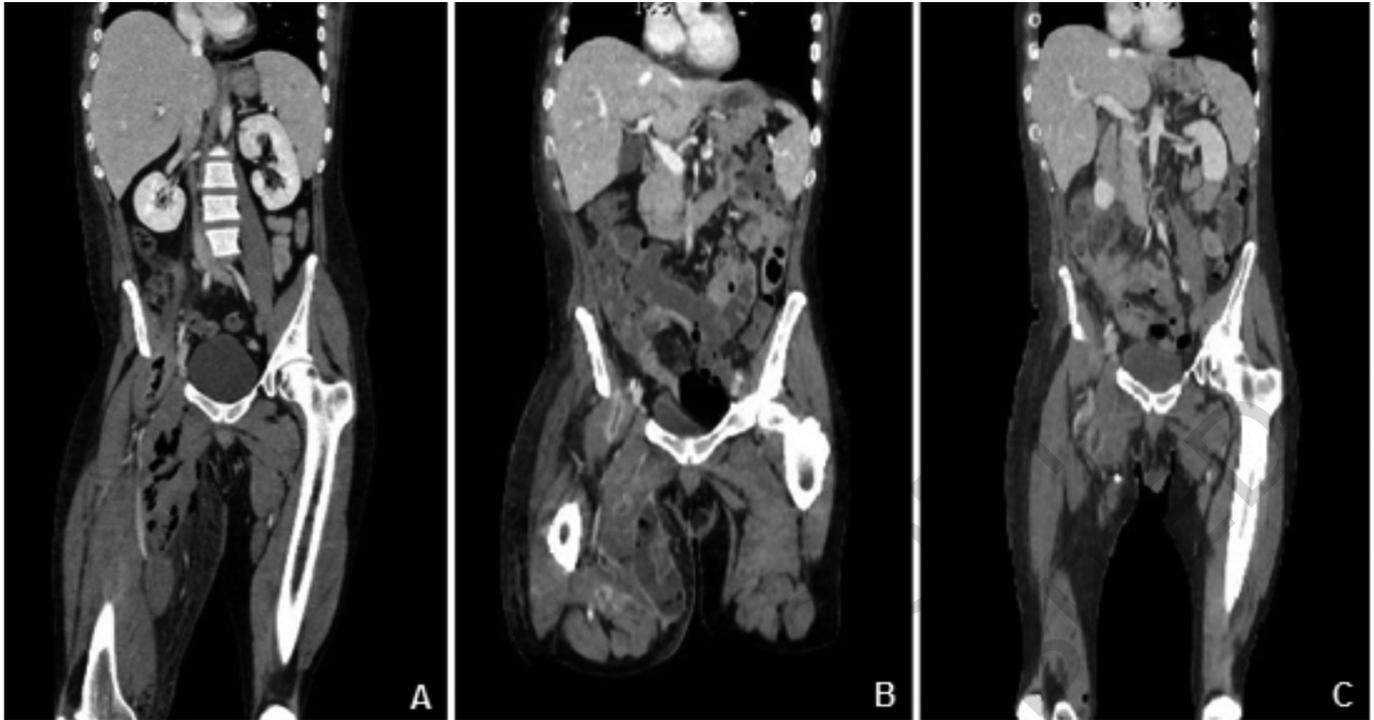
A) CT scan upon admission revealed a large complex air-fluid collection within the right iliac region, involving terminal ileum, right retroperitoneum and right lateral abdominal wall towards the inner edge of the right thigh; B) CT scan, seventeen days after surgery, showed few residual air-fluid collections within the inner edge of the patient's right thigh, involving iliacus, pectineus, adductor and sartorius muscles towards both the subcutaneous and cutaneous tissues anteriorly. Therefore, the radiologist using the imaging guidance placed a 10 French percutaneous abscess drainage in the biggest and declivous collection of the right thigh; C) One week later a new CT scan showed a significant downsizing of the right inferior limb collection and the drainage was soon after removed.
